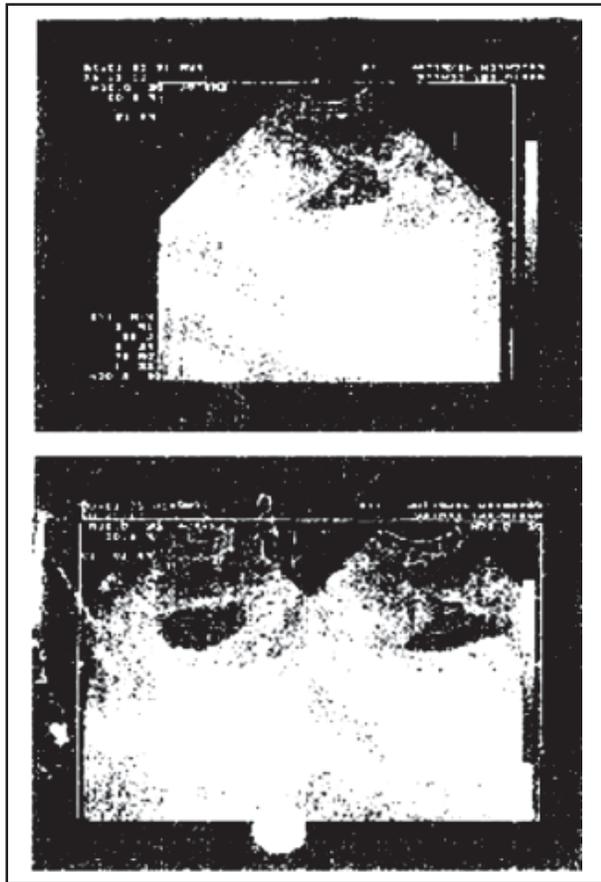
Gestational sac in cervix in transvaginal sonography.
